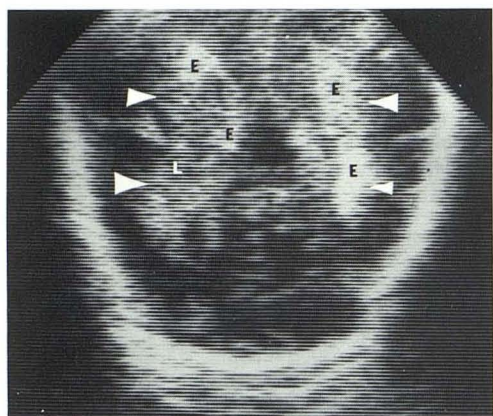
Case 2. Semiaxial sonogram, 2 days of age. Bilateral periventricular hemorrhage (arrowheads). Inhomogeneous hemorrhagic echo pattern; some areas are extremely echogenic (E), others less echogenic (L).
